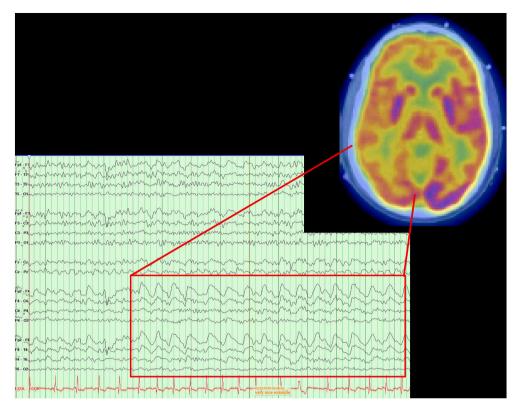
Brain regions corresponding to EEG abnormalities are typically hypometabolic in neurotoxicity. EEG demonstrates focal slowing in a patient with intermittent left visual field deficit and left arm numbness with corresponding cortical hypometabolism on FDG-PET scan.
